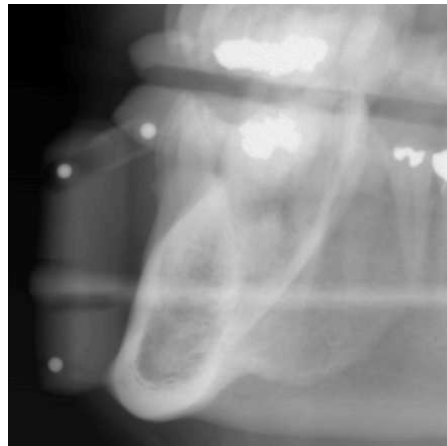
One (mandibular) projection radiograph of the patient.
